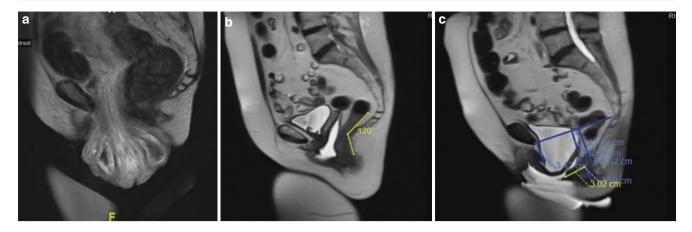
(a) Sigmoidocele through vagina on MRI. (b) MR defecography at rest (and measurements). (c) MR defecography with rectocele (and measurements)
